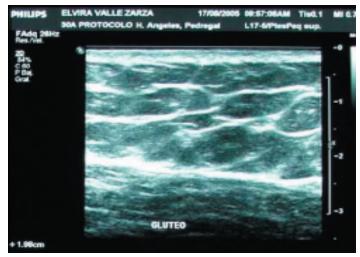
Ultrasound of Subcutaneous Tissue 15 days after Second Treatment.
